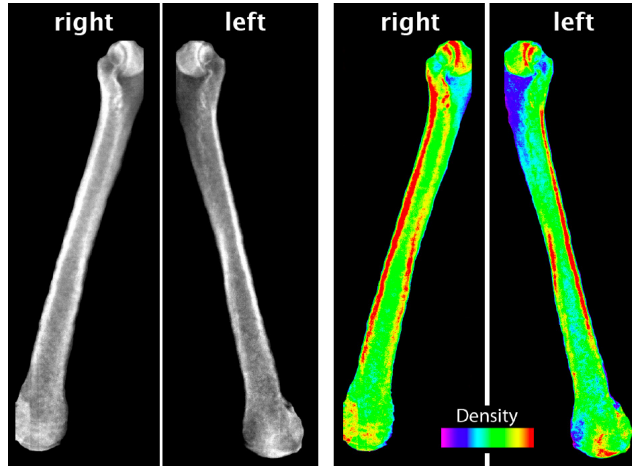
Representative X-ray images of right and left humerus of high performance tennis player.
